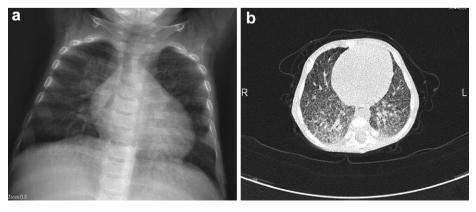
CXR (a) and HRCT (b) of patient no. 3.
